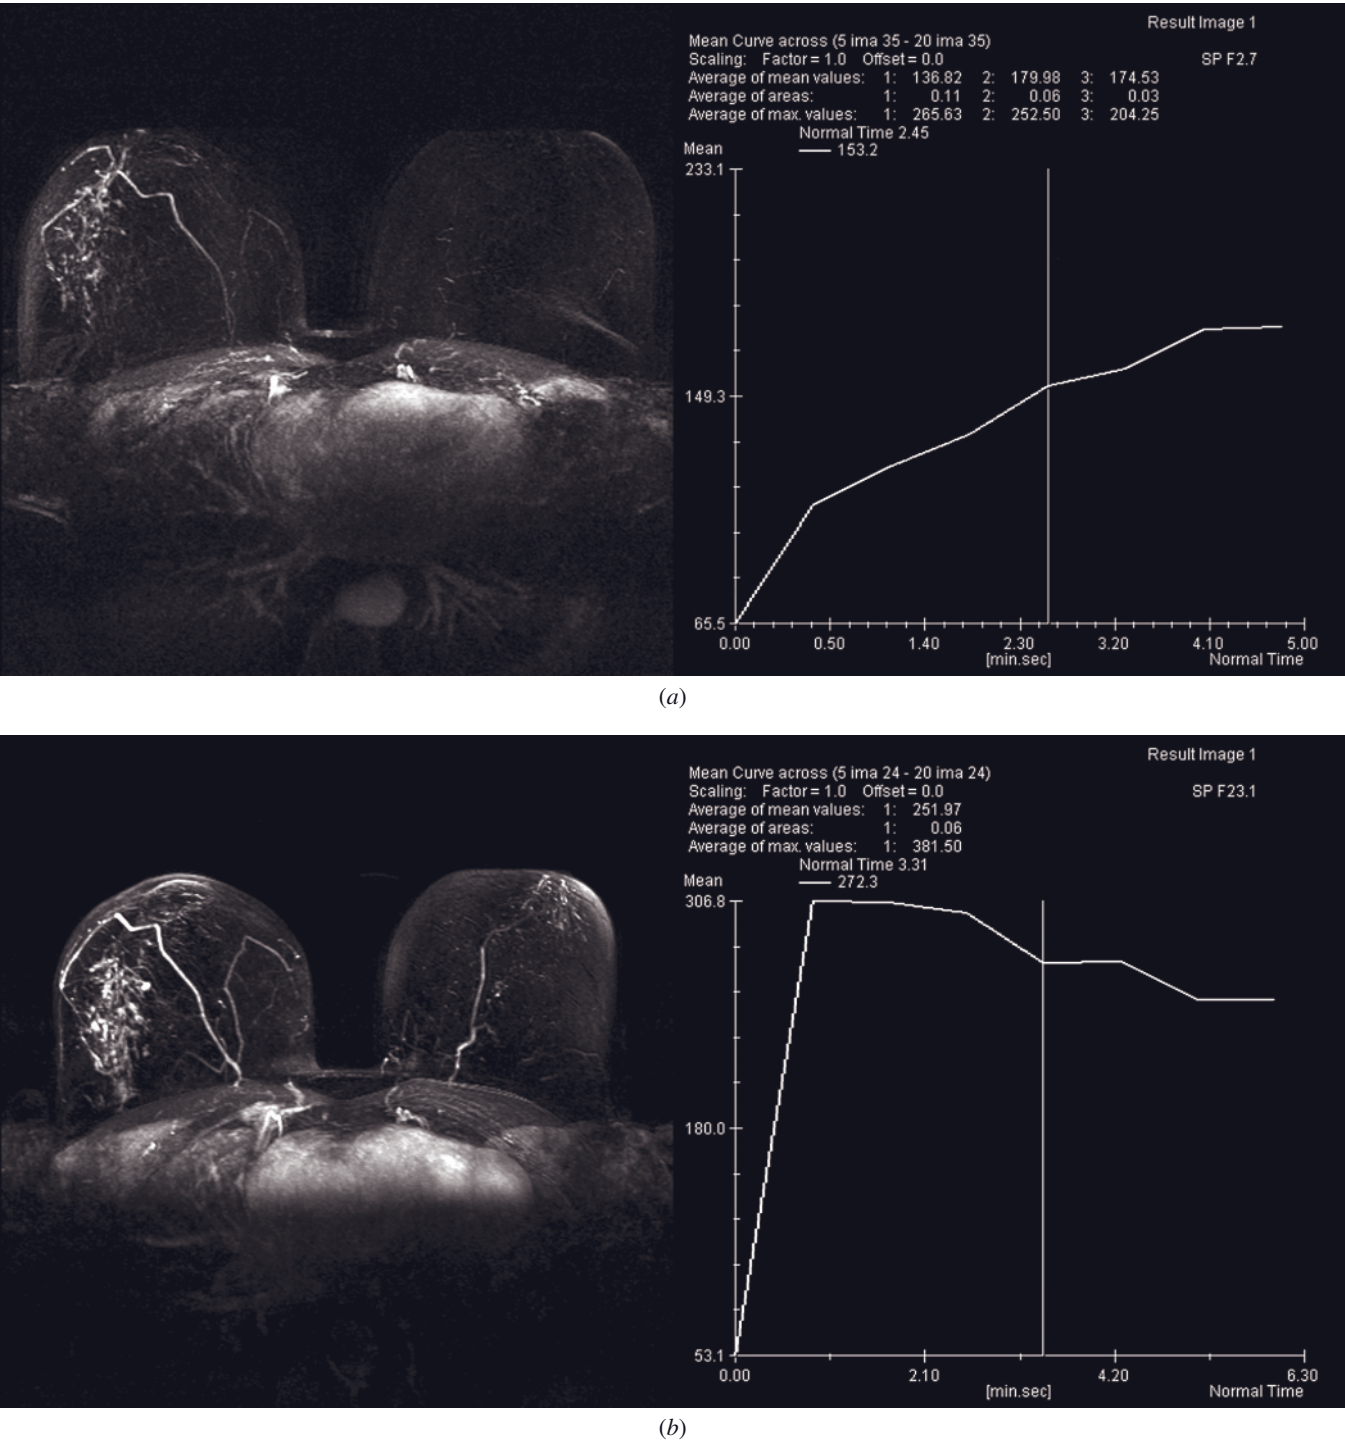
Ductal carcinoma in situ (DCIS). MIP image (a) shows a non-masslike enhancement in segmental distribution within the right breast, with persistent kinetic curve. Since the patient refused biopsy, follow-up with another MRI study was performed after 6 months (b) showing significant increase in the non-masslike segmental enhancement typical for DCIS. Furthermore, the ROI analysis of this study reveals the alteration from persistent (Type D) to washout (Type III) type curve. Subsequent biopsy verified high-grade DCIS with multiple small foci of invasive ductal carcinoma (IDC).
